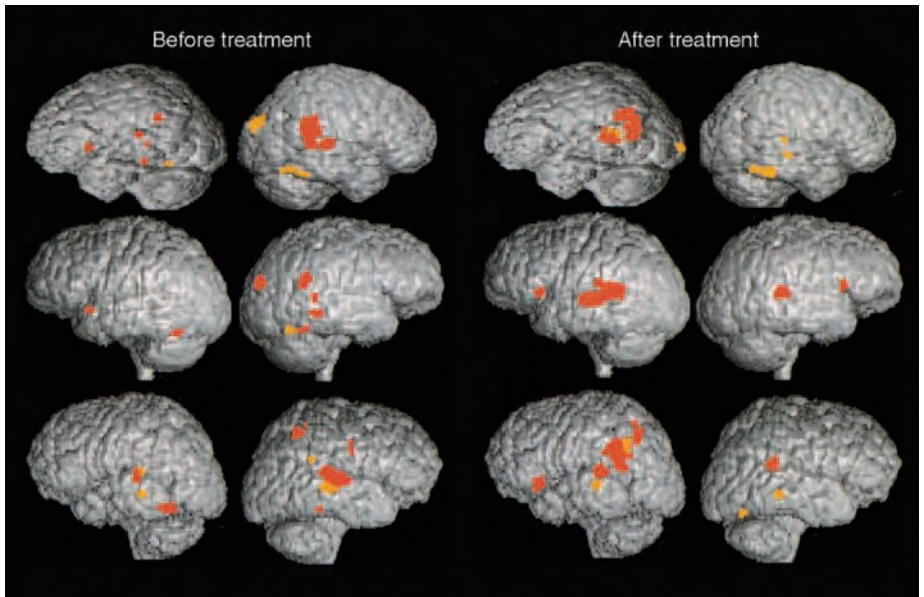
Magnetic source imaging where magnetoencephalography (MEG) activation is integrated with 3-D structural magnetic resonance imaging (MRI) is depicted in three different patients with dyslexia prior to intervention. As shown in the 'Before Treatment' column, little activation occurred in the traditional language regions of the left hemisphere. In contrast, as shown in the 'After Treatment' column, increased engagement of left hemisphere language areas occurs. This demonstrates the potential use of neuroimaging to track treatment effects. (Adapted with permission from Simos *et al.*, 2002.)
